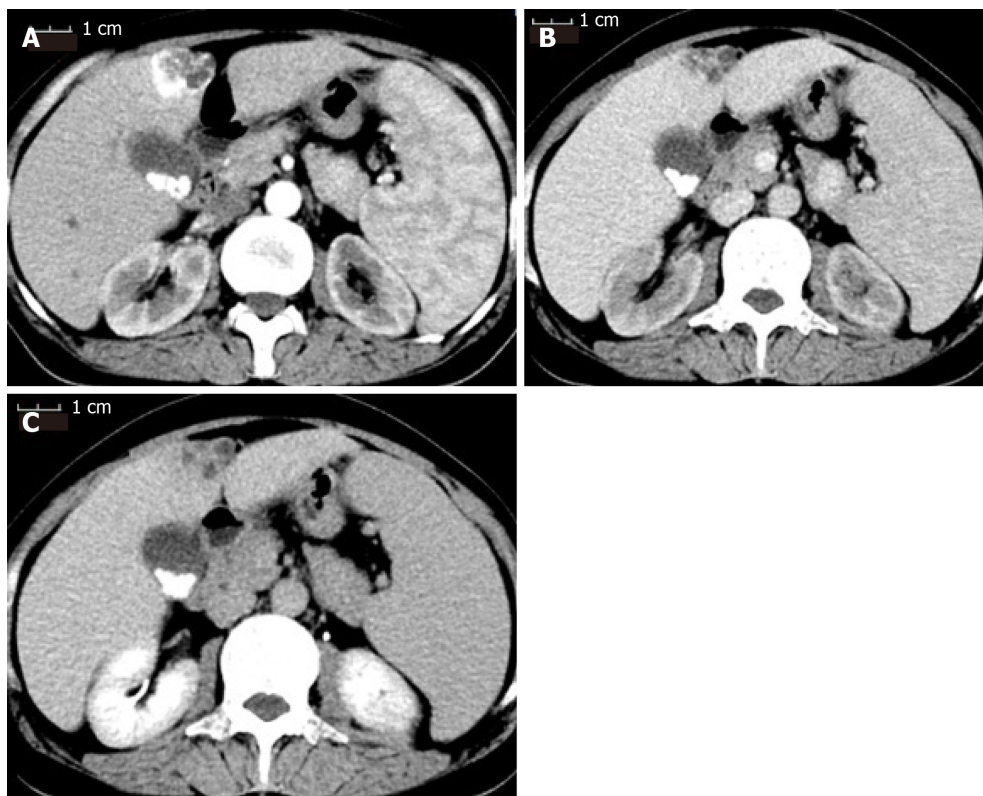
Contrast-enhanced computed tomography scan of the patient before receiving transarterial chemoembolization. A: The mass was enhanced immediately during the arterial phase; B: The enhancement faded away quickly into equal density in the portal venous phase; C: The mass showed hypodensity in the delayed phase. The three phases of the computed tomography scan also showed multiple gallstones and splenomegaly.
